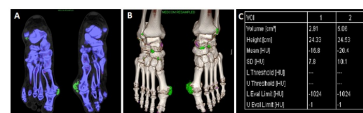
Dual-energy CT images from a chronic tophaceous gout patient (A). Three-dimensional DECT image (B). Automated urate volume measurement using software (C).
